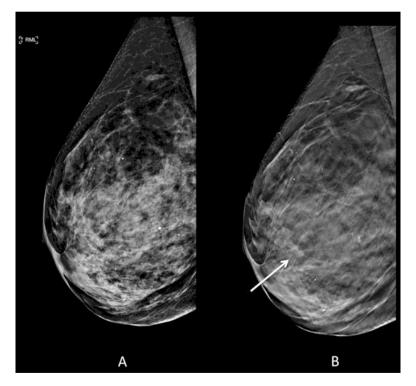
Seventy-six-year-old woman with dense breast parenchyma for annual full-field digital mammogram with digital breast tomosynthesis (DBT). (a) Conventional 2D lateral view is negative for malignancy. (b) Architectural distortion (*arrow*) is identified only on DBT image. A mass was seen on subsequent ultrasound (not shown) with subsequent biopsy pathology of grade 1 invasive ductal carcinoma
